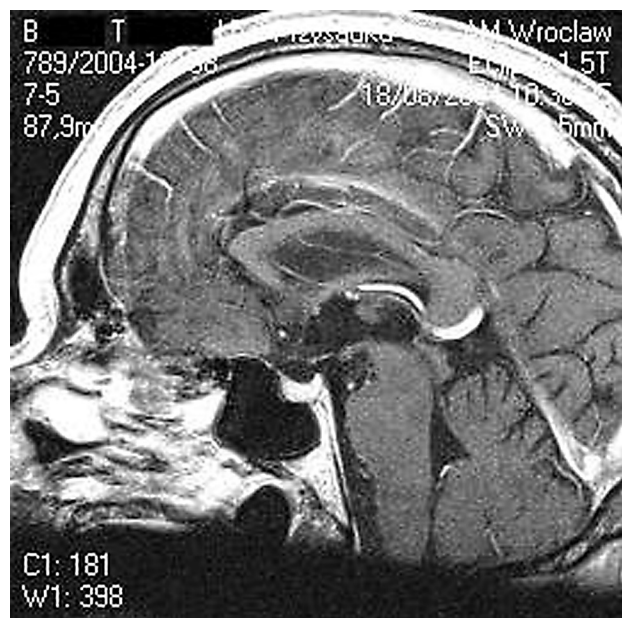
(MR 18.08.2004) The same examination: sagittal contrast-enhanced T1-weighted image. Complete regression of the lesion within the optic chiasm
